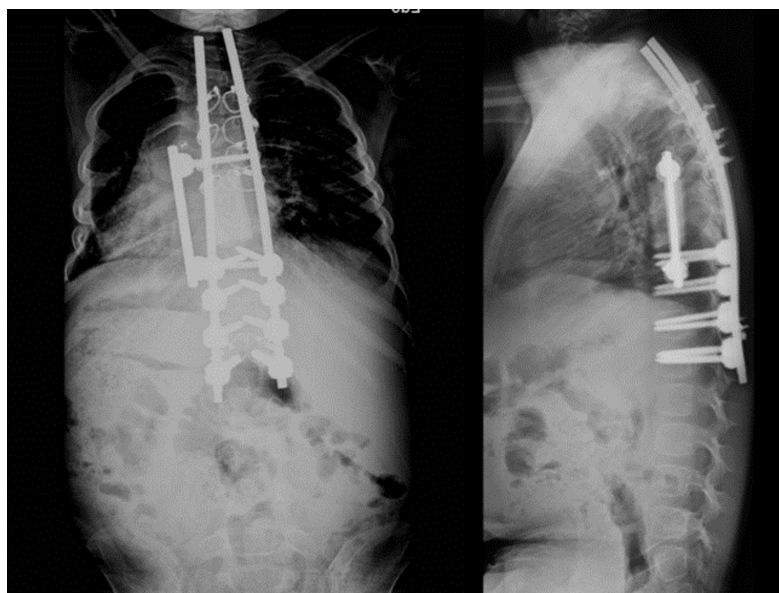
Panoramic radiograph of the AP and lateral spine showing the result after two-stage surgical management with autologous tibial graft and posterior transpedicular instrumentation in a posterior approach.
